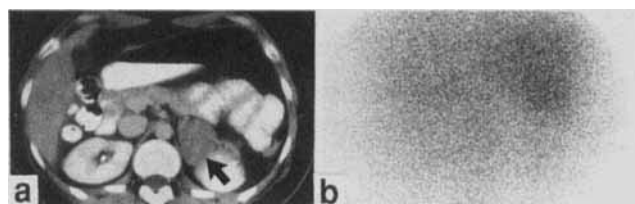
a Abdominal computed tomography scan identifies a 7 cm left adrenal mass (arrow). b Posterior ^{131}I -6- β -iodomethyl-19-norcholesterol scan depicts no discernible adrenal uptake in a patient with a primarily androgen-secreting adrenocortical carcinoma
